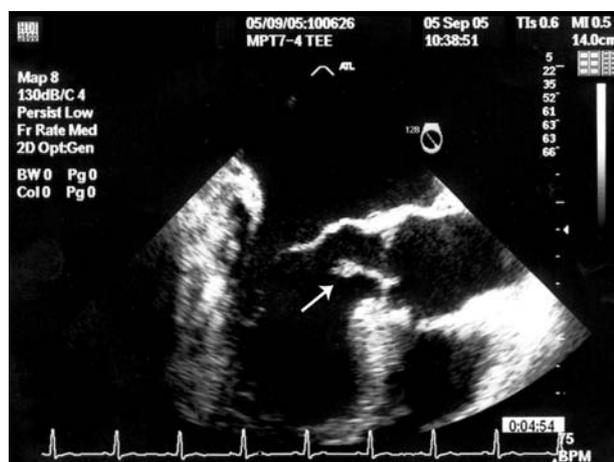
Transoesophageal echocardiogram showing characteristic imaging of the vegetation (arrow).
